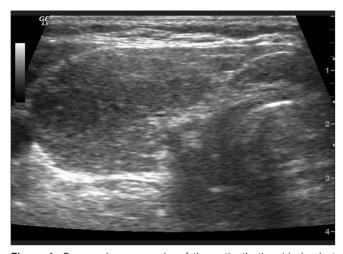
Gray-scale sonography of the patient's thyroid gland at presentation (right lobe, transverse view)
